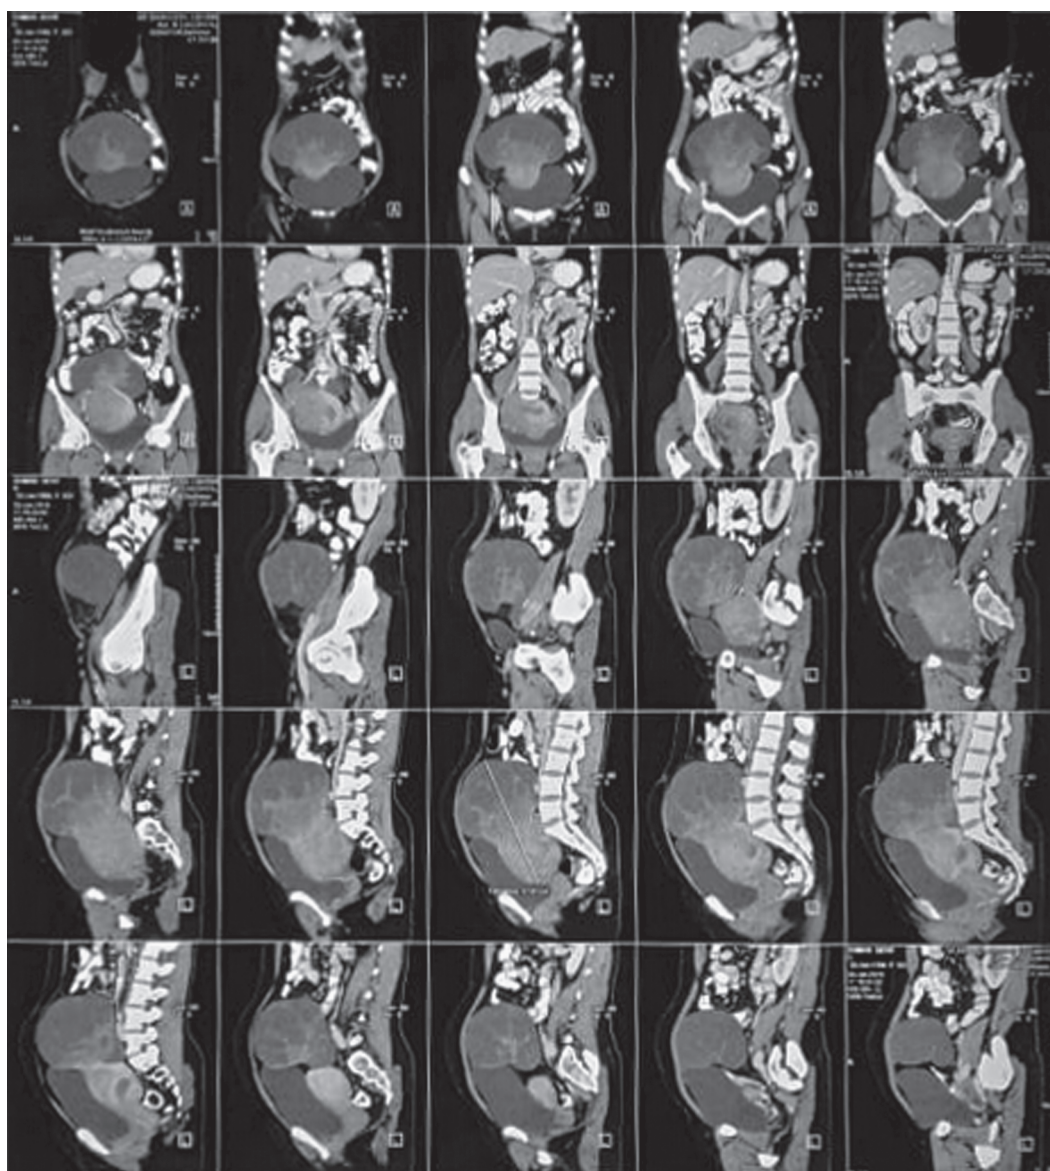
Computed tomography scan showing a huge mass arising from fundal region of uterus
